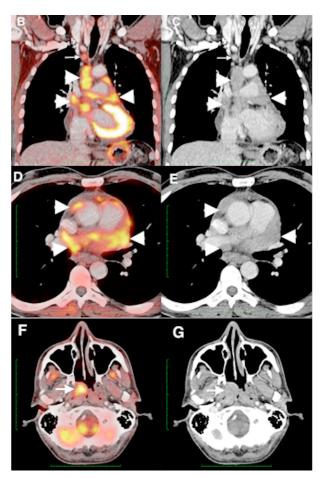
B-G. Low dose of IV contrast was administered. PET/CT images including fusion (B, D, F) and CT (C, E, G) revealed increased FDG uptake (SUVmax=8.3) in partly nodal and diffuse thickening in mass areas at pericardial zones (arrowheads).
